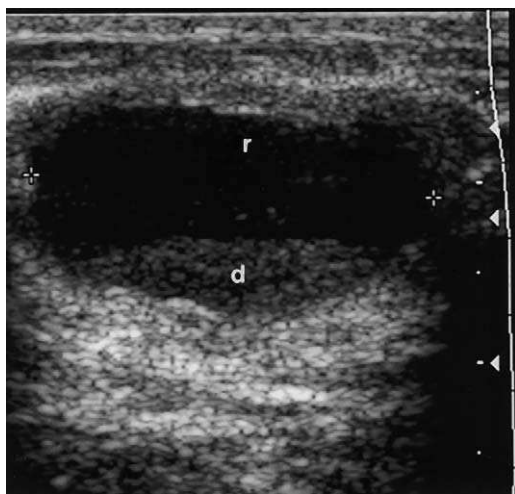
Complicated cyst. Calipers mark a “complicated” cyst with debris (d) at its dependent portion and reverberation artifact (r) anteriorly. This cyst was aspirated with ultrasound guidance for symptomatic relief to complete resolution.
